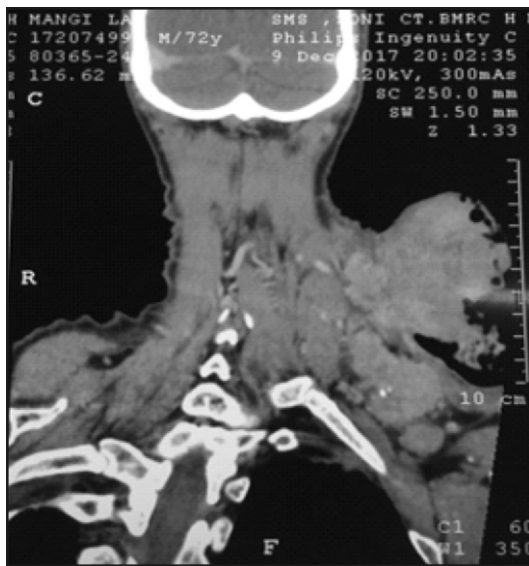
CT scan of neck.
